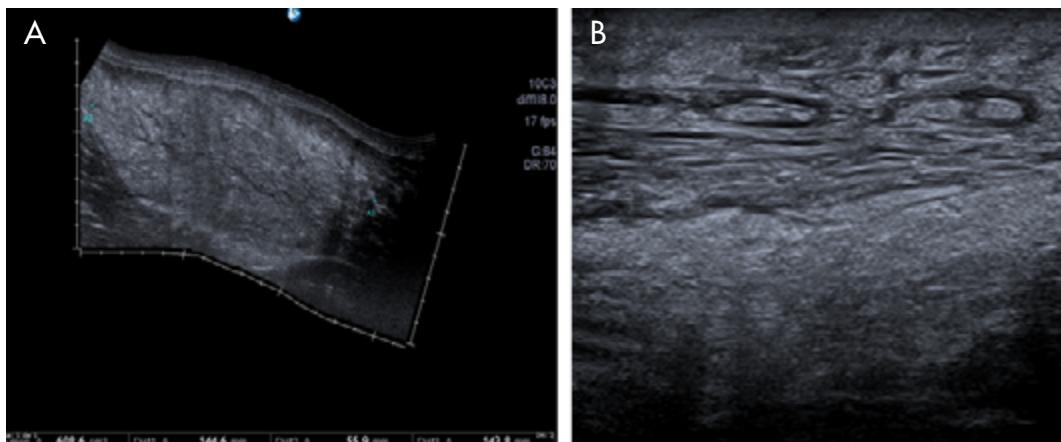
Ultrasound of the left gluteal soft tissue. A) axial plane of the left gluteus maximus muscle; B) axial plane of the subcutaneous adipose tissue from the superficial left gluteal region to the muscle.
